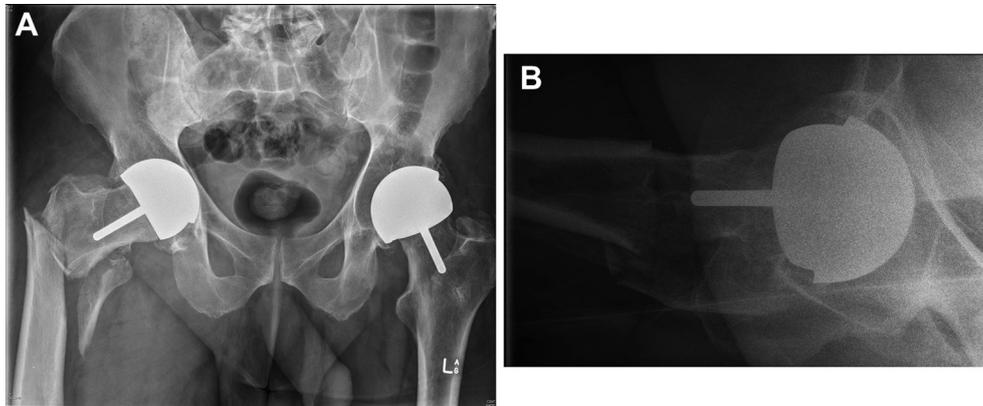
Initial X-rays showing periprosthetic intertrochanteric fracture: (A) anteroposterior and (B) lateral radiographs.
